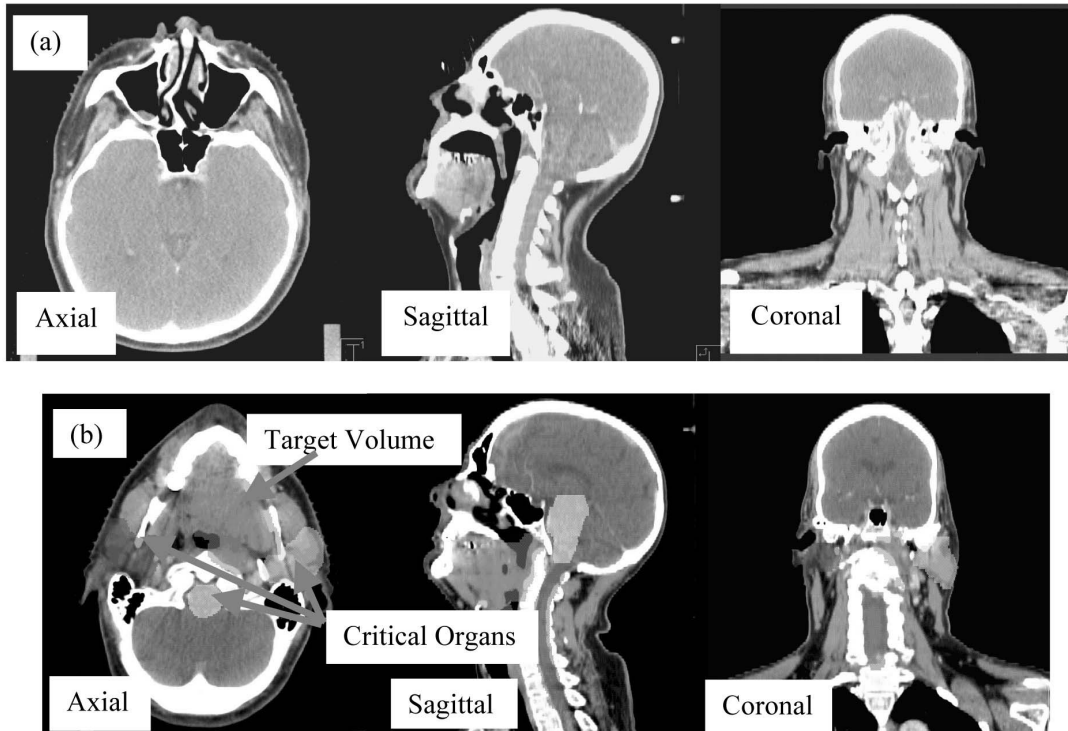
CT Image is Typically Displayed in Three Views, Axial (Cross section in Head to Feet Direction When a Patient Lies on the Table), Coronal (Cross Section in Front to Back Direction) and Sagittal (Cross Section in Left to Right Direction). (a) CT Images of a Head and Neck Site (b) CT Images With Target and Critical Organ Volumes
